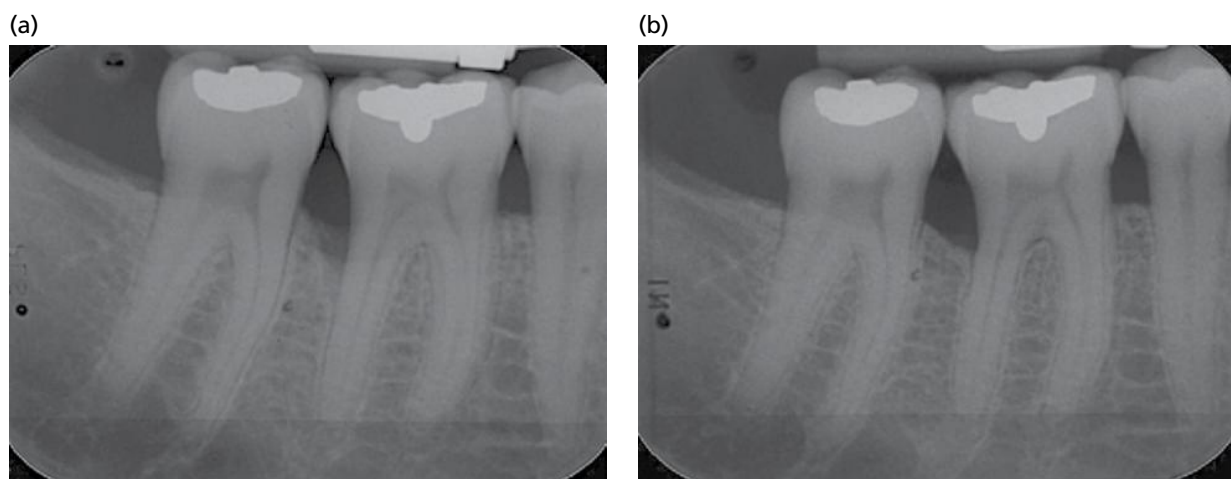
Radiographs at the final examination of the patient presented in Fig. 32-17.
